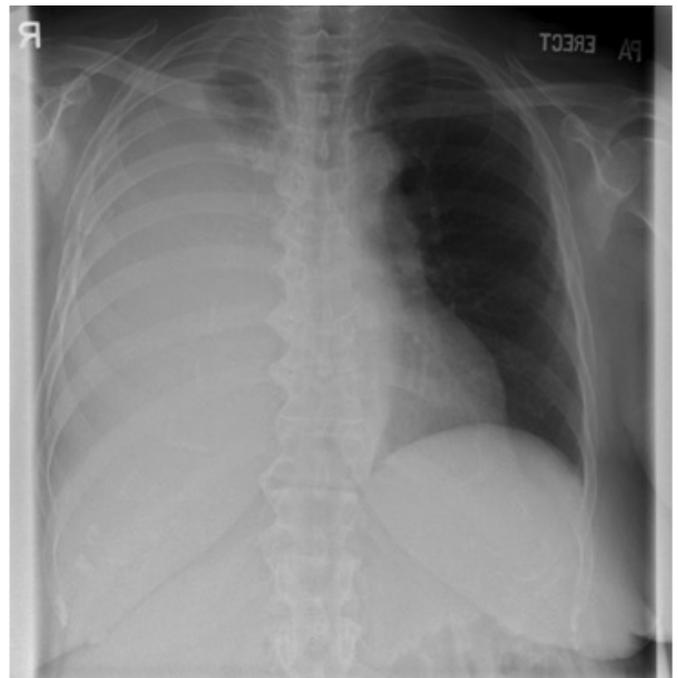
Initial Chest x-ray showing massive right pleural effusion.
